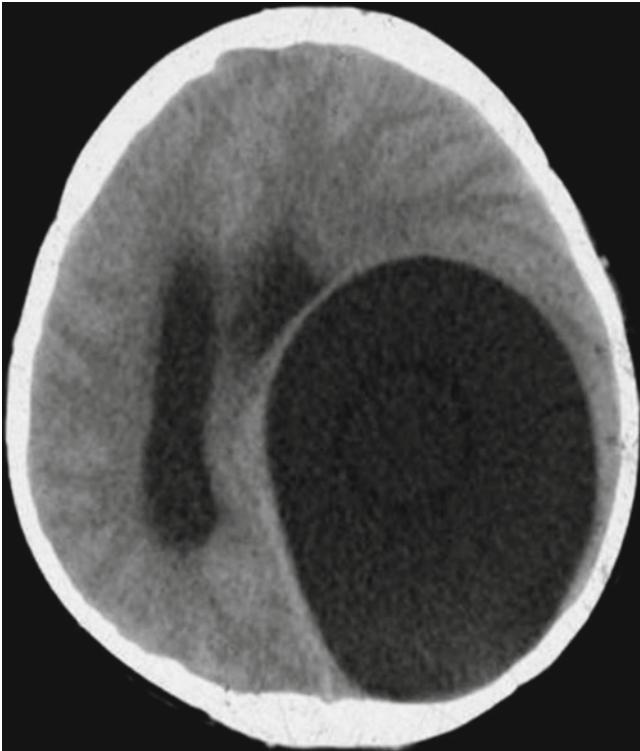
Cerebral cystic echinococcosis. CT scanning demonstrates giant cystic space-occupying lesion in the brain, with smooth and regular cystic wall, homogeneous intracystic density, rightward shift of the midline structures, dilated bilateral ventricles, deformed left ventricle due to compression, and no obvious edema around the lesion
